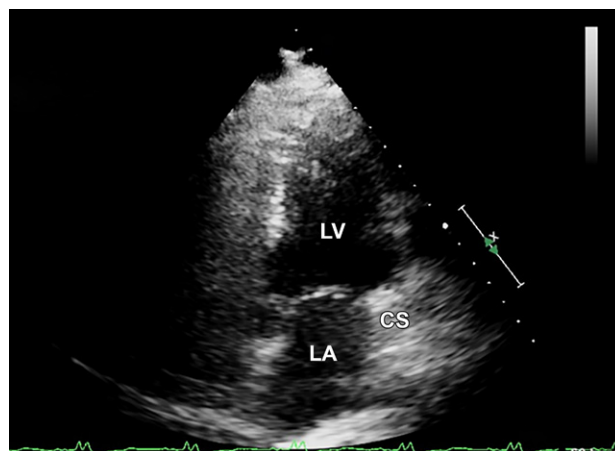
Transthoracic echocardiogram after agitated-saline injection shows opacification of the coronary sinus (CS) preceding opacification of the right atrium.
